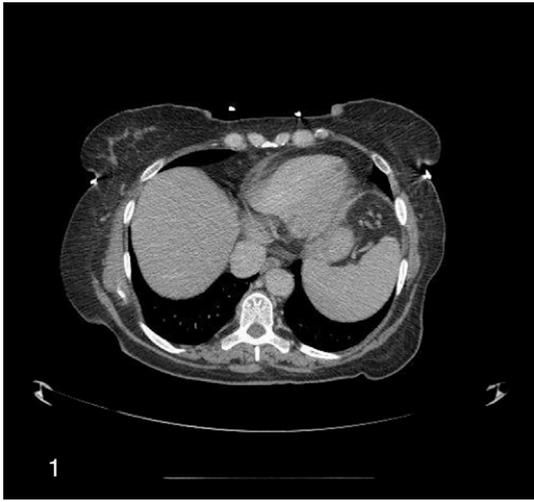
Computed tomographic scans of the abdomen and pelvis show a right hepatic heterogeneous mass.
